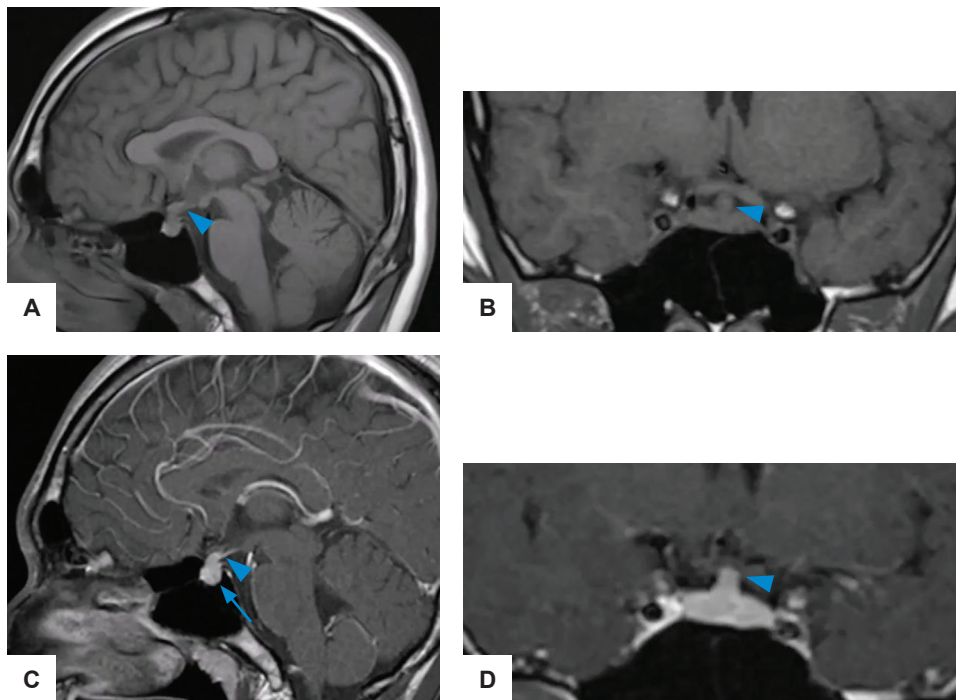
Magnetic resonance imaging of hypothalamic-pituitary regions in 2016 (A-D). Thickening of pituitary stalk measuring 6 mm (arrowheads) and absence of posterior pituitary bright spot (arrow) at initial presentation (A, B) non-contrast T1-weighted; (C, D) contrast-enhanced.
